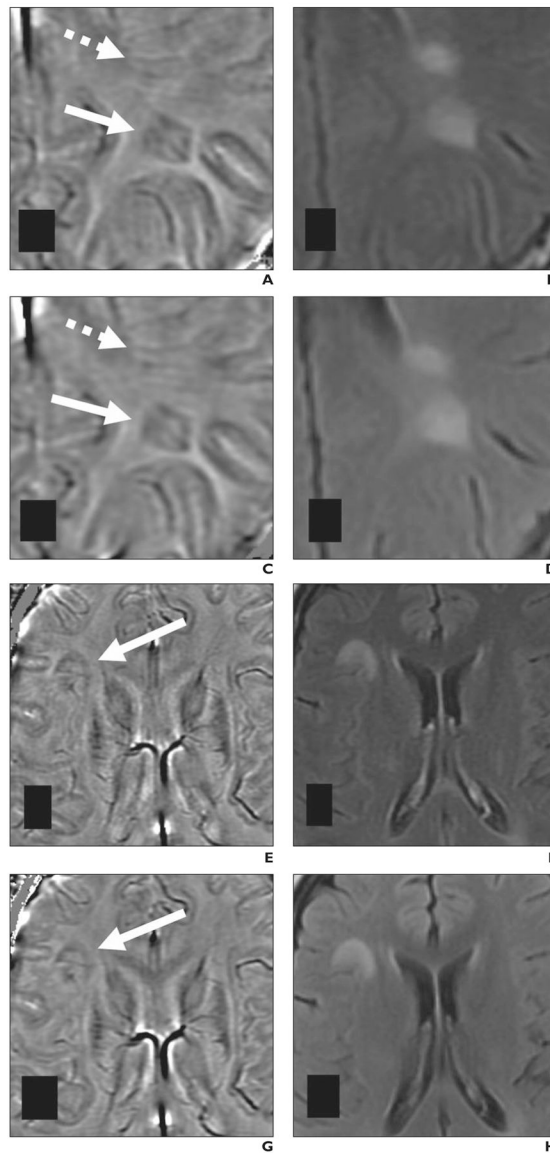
Paramagnetic rim lesions detected at 1.5-T and 3-T MRI in 28-year-old woman (patient 3 in Table 1) with multiple sclerosis. Both MRI examinations included susceptibility-weighted angiography (SWAN, GE Healthcare) sequence; 1.5-T MRI was performed 2 months before 3-T MRI.
